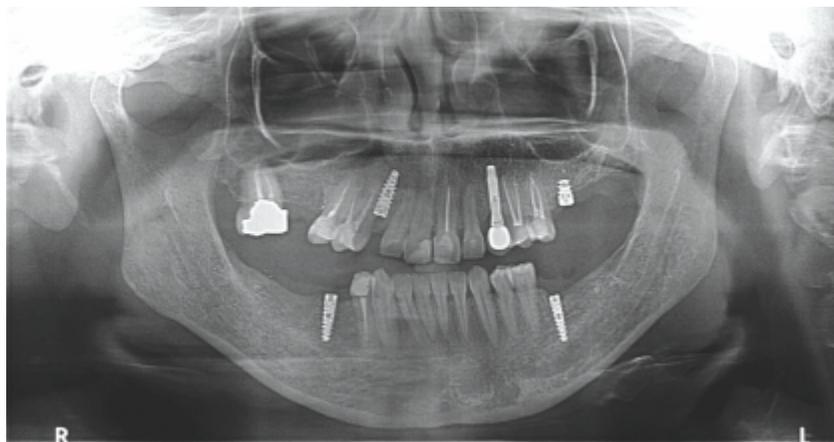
Orthopantomograph after four months
